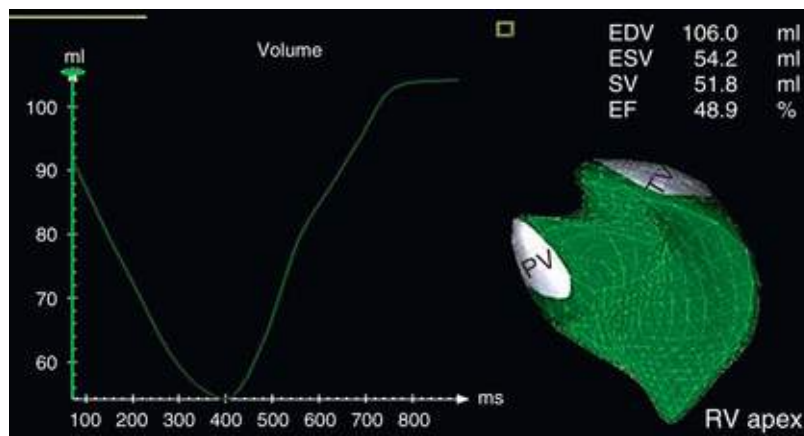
Three-dimensional measurements of right ventricular (RV) volume and function. A 3D echocardiographic reconstruction of the RV shape and volume, as viewed from the septal surface. The graph at *left* shows RV volumes plotted against time over the cardiac cycle, with data obtained from RV-focused apical four-chamber windows. RV stroke volume (SV) = EDV – ESV. RV ejection fraction (EF) = SV/EDV. EDV, end-diastolic volume; ESV, end-systolic volume; PV, pulmonic valve; TV, tricuspid valve.
